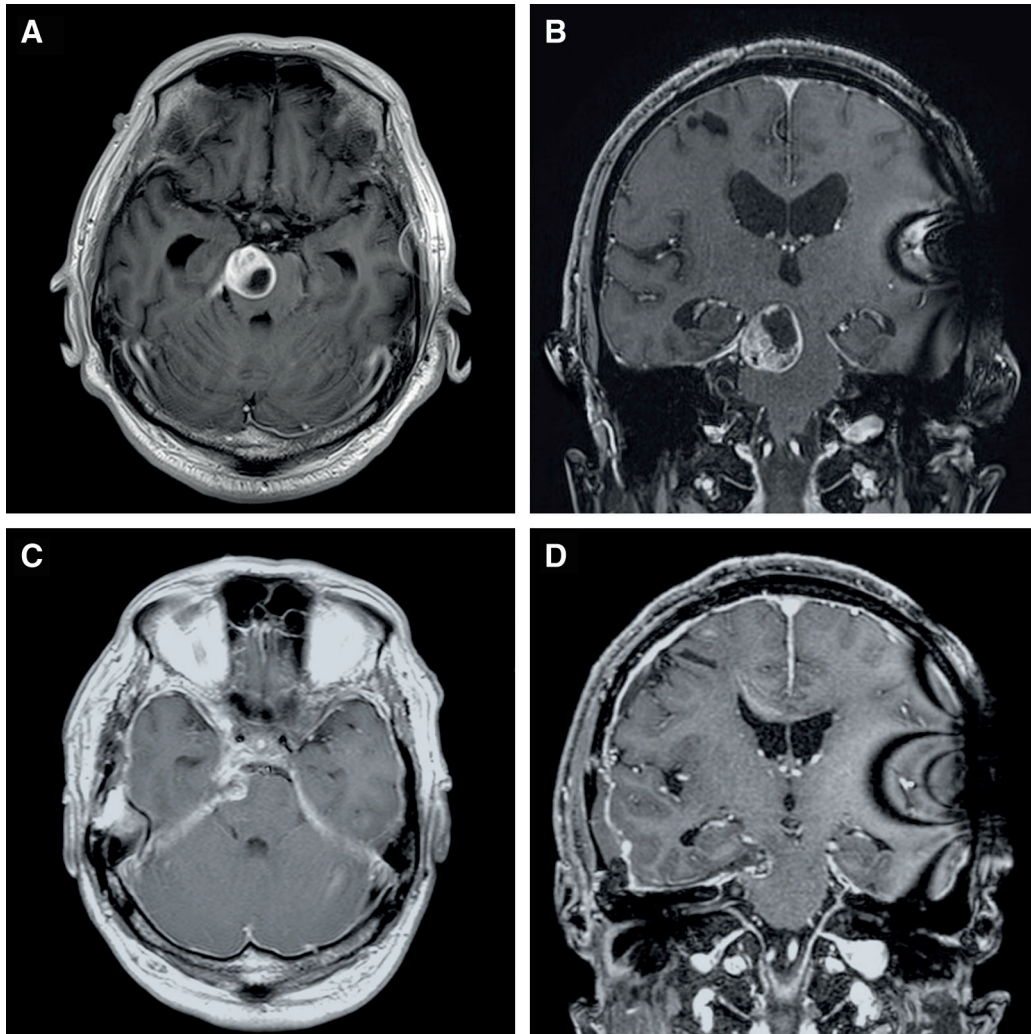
Preoperative T1-weighted contrast MRI. MRI findings showing a mass measuring $25 \times 22 \times 25$ mm at the right lateral of the midbrain with a heterogeneously enhanced and partially included cystic change are presented (A and B). Postoperative T1-weighted contrast MRI showing a residual tumor adherent to the brainstem (C and D).
